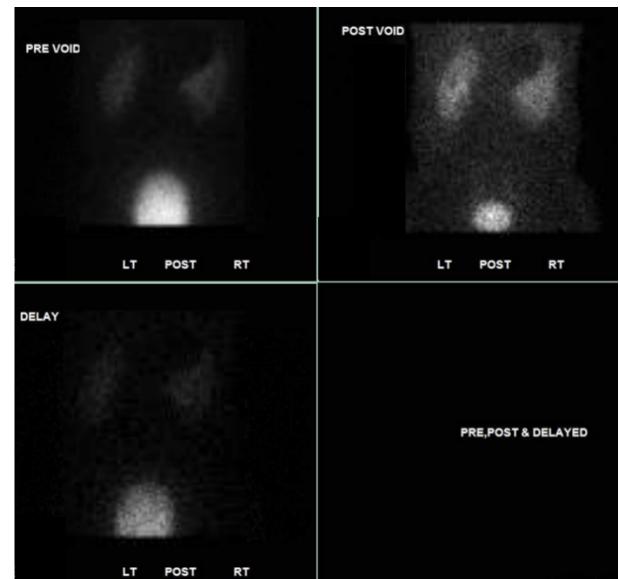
NM Renal MAG3 scan five months following sclerotherapy, showing normal left kidney function with no scintigraphic evidence of obstruction.
